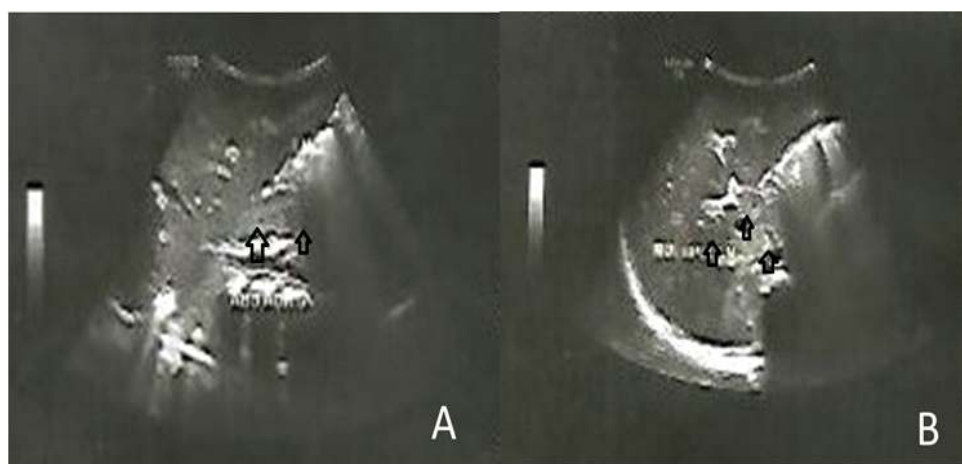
Ultrasound images (A & B) showing multiple peri-porta hepatic, and para-aortic regions lymphadenopathy as labelled with the black arrows.
